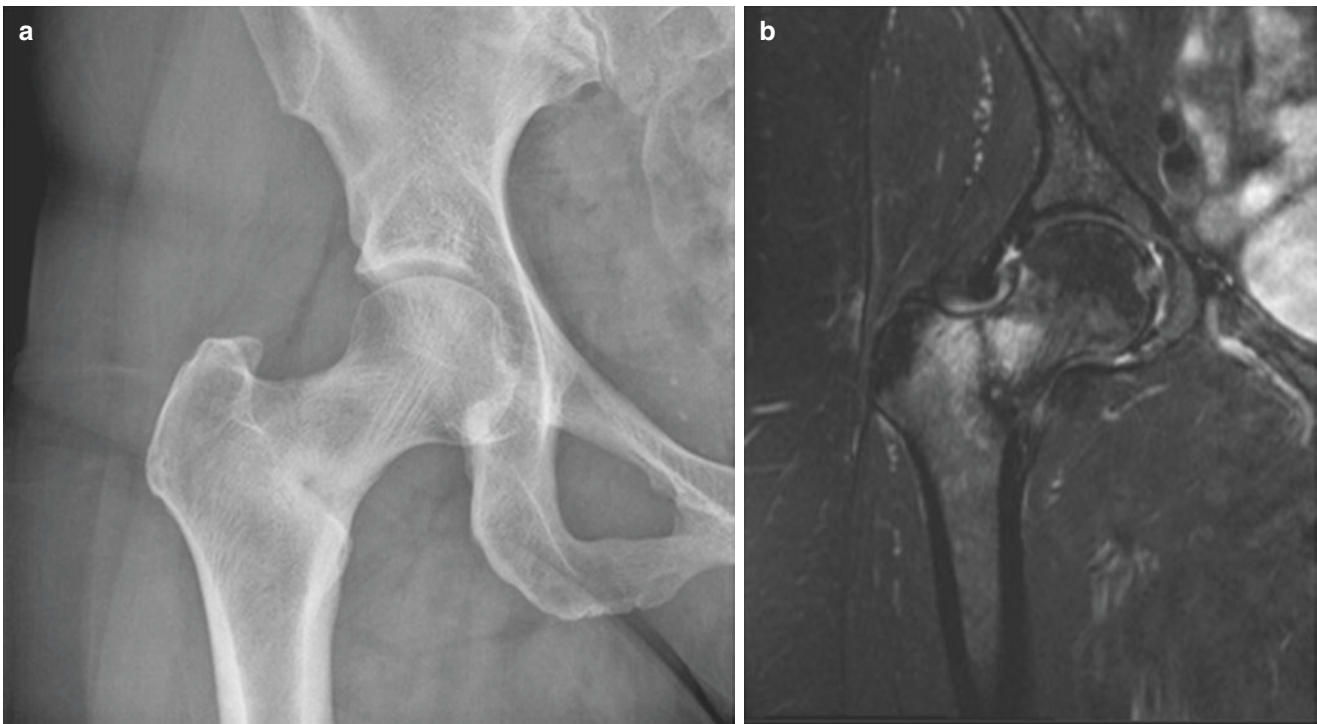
(a) Anteroposterior radiograph of the hip in a 47 year-old female marathon runner with tension side femoral neck stress fracture with early callus formation. (b) T2 coronal MRI demonstrating nondisplaced transverse femoral neck stress fracture in a 47 year-old female marathon runner
